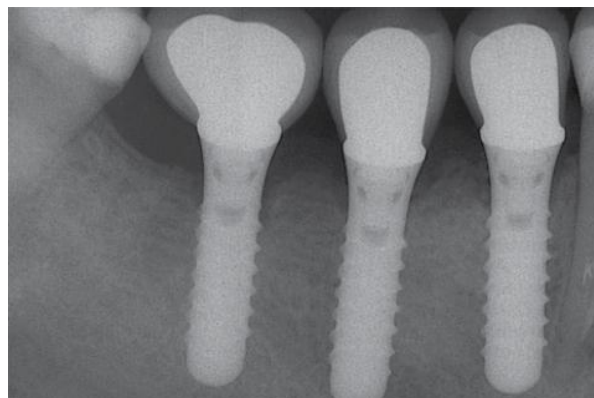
(Continued) (d) Radiograph of the two splinted implants after 1 year in function.
